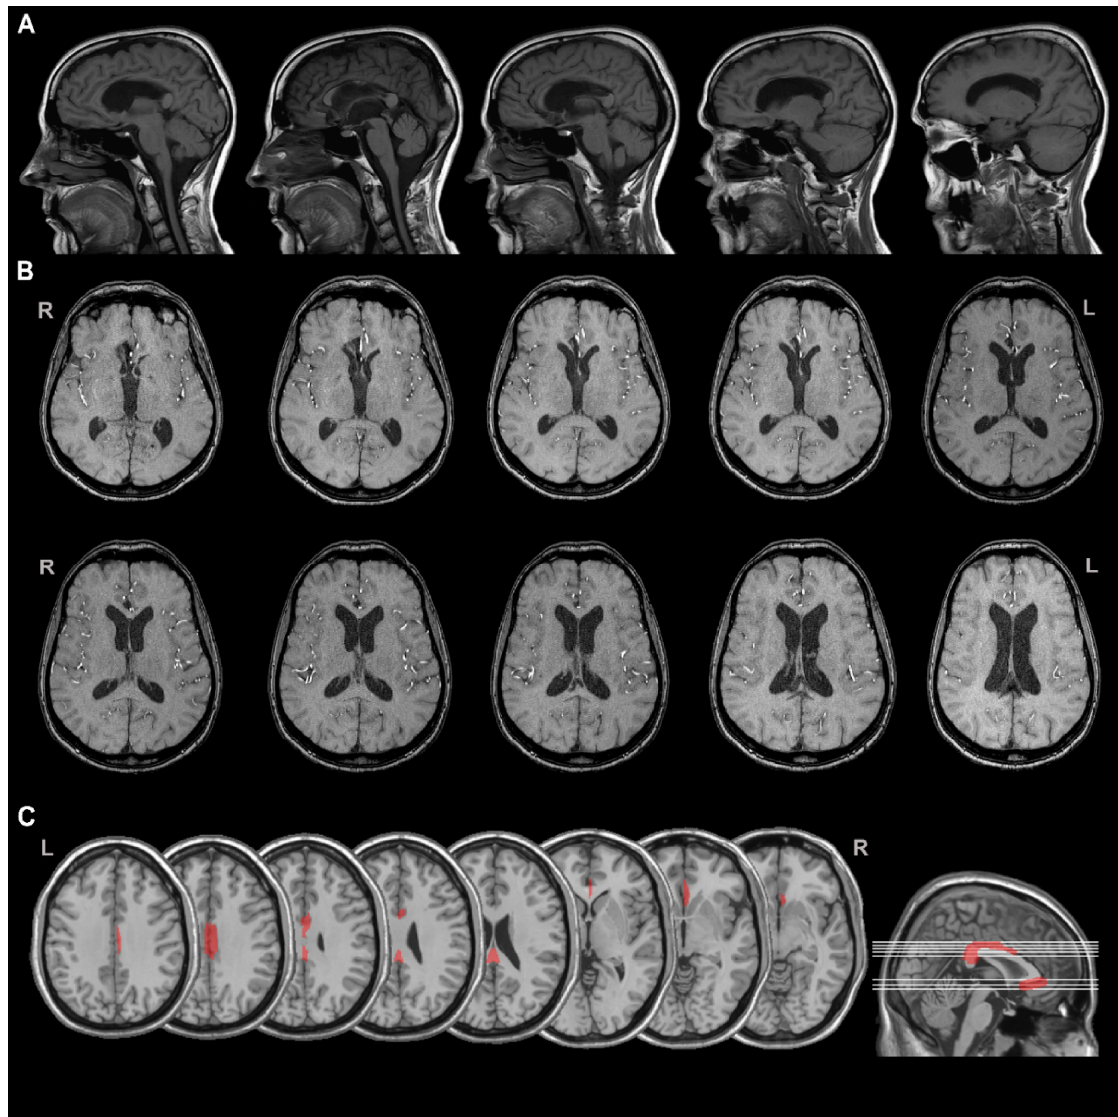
MRI scans of the patient TP in sagittal (A) and horizontal (B) view. C. Patient's lesion reconstruction. Mapping of the brain lesions was performed by MRlcro (Rorden and Brett, 2000). Lesions, as documented by the most recent MRI, were traced on the T1-weighted template MRI scan from the Montreal Neurological Institute provided with the MRlcro software.
